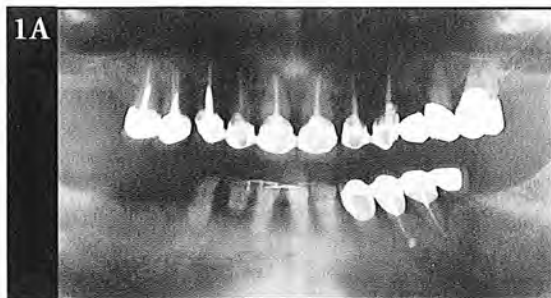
A preoperative radiograph indicates that all teeth are severely periodontally involved with a hopeless prognosis.
